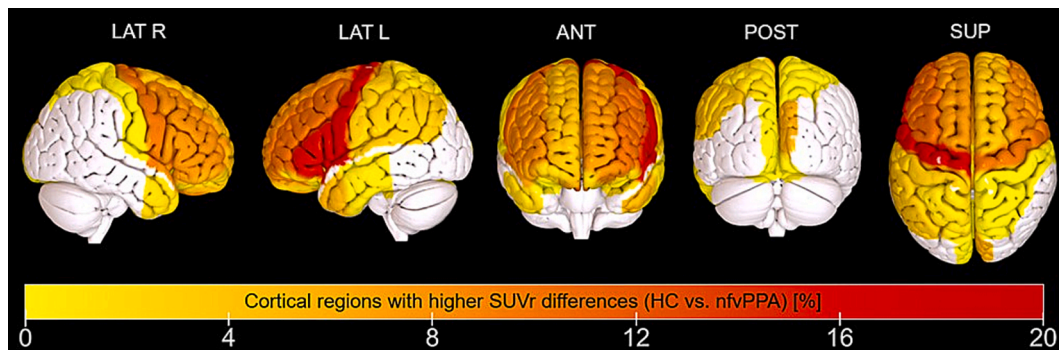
Cortical regions with higher differences between HC and nfv-PPA patients before and after PVEC (difference of higher uptake in nfv-PPA compared to HC in %) in three-dimensional surface projections of the brain. nfv-PPA = non-fluent/agrammatic primary progressive aphasia; HC = healthy control; SUVR = standard uptake value ratio; LAT = lateral; ANT = anterior, POST = posterior; SUP = superior; R = right; L = left.
